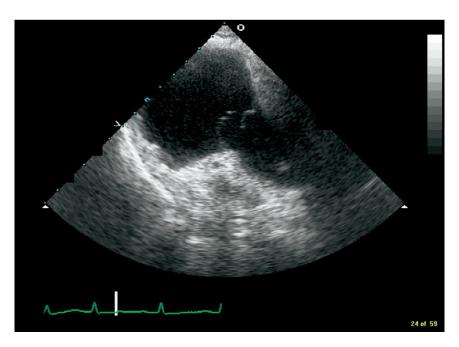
Transesophageal echocardiogram from midesophagus 45-degree angle showing flail anterior tricuspid valve leaflet caused by blunt thoracic trauma.
